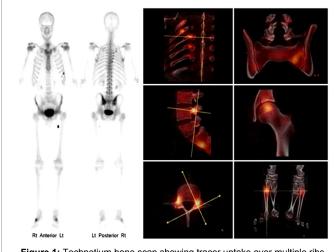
Technetium bone scan showing tracer uptake over multiple ribs in an asymmetrical pattern, both pedicles of L4 vertebra, left sacral alae, femoral head, and metatarsals. upper and lower gastrointestinal, as well as capsule endoscopy and small bowel biopsy. He had low haemoglobin (62 g/L), serum ferritin (11  $\mu$ g/L) and bone marrow iron stores, and received parenteral ferrous carboxymaltose (FCM) infusions every 8 weeks for about four years. Protein electrophoresis showed no changes and myeloma screen was negative. Thoracic spine CT and whole body PET scan excluded malignancy. Bone densitometry showed mild osteopenia (lumbar spine T-score-1.8 and femoral neck T-score-0.7). He was referred for endocrine evaluation.
